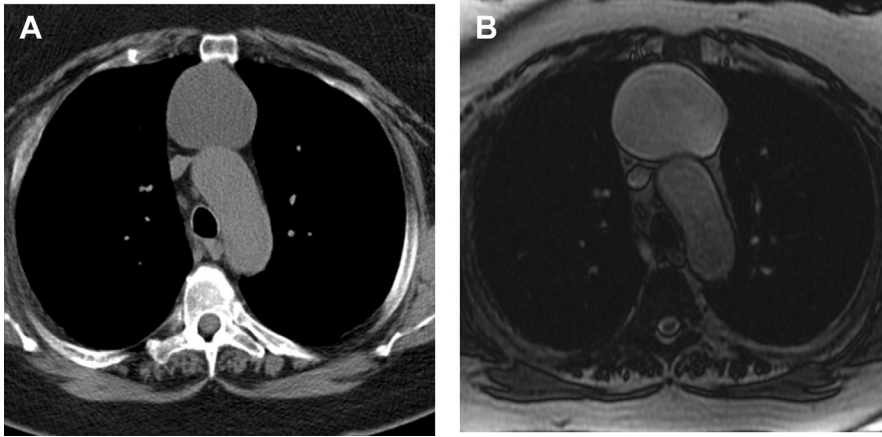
Thymic cyst. (A) Unenhanced axial CT shows a large water attenuation mass in the prevascular mediastinum. (B) Axial T2-weighted MR image shows a thin-walled cyst with homogeneous high signal intensity throughout the lesion, consistent with a simple thymic cyst.
